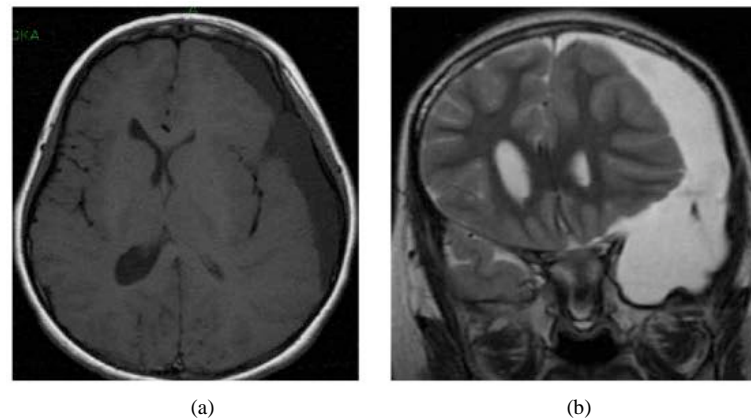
Magnetic resonance imaging (MRI) of the head at admission revealed that the intensity of the subdural hematoma was iso-hyperintense on a T1-weighted image (T1-WI) (a) and hyperintense on T2-WI (b), suggesting a hematoma in the chronic phase.
